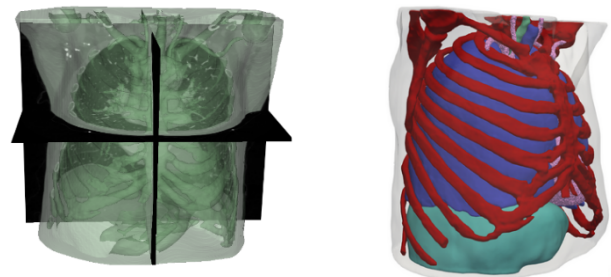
Left: Segmentation of the thoracic CT scan consisting of 35 distinct labels. Right: The tetrahedral mesh of the segmented scan.
